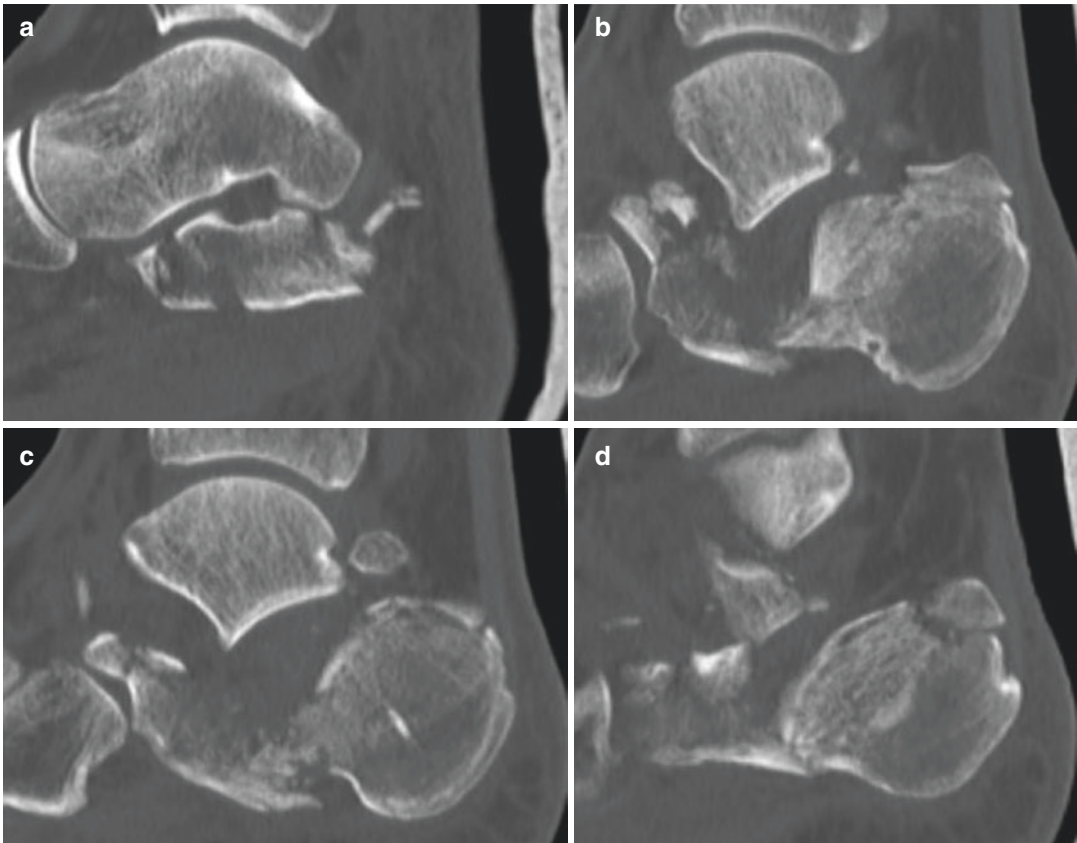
Sagittal CT images
